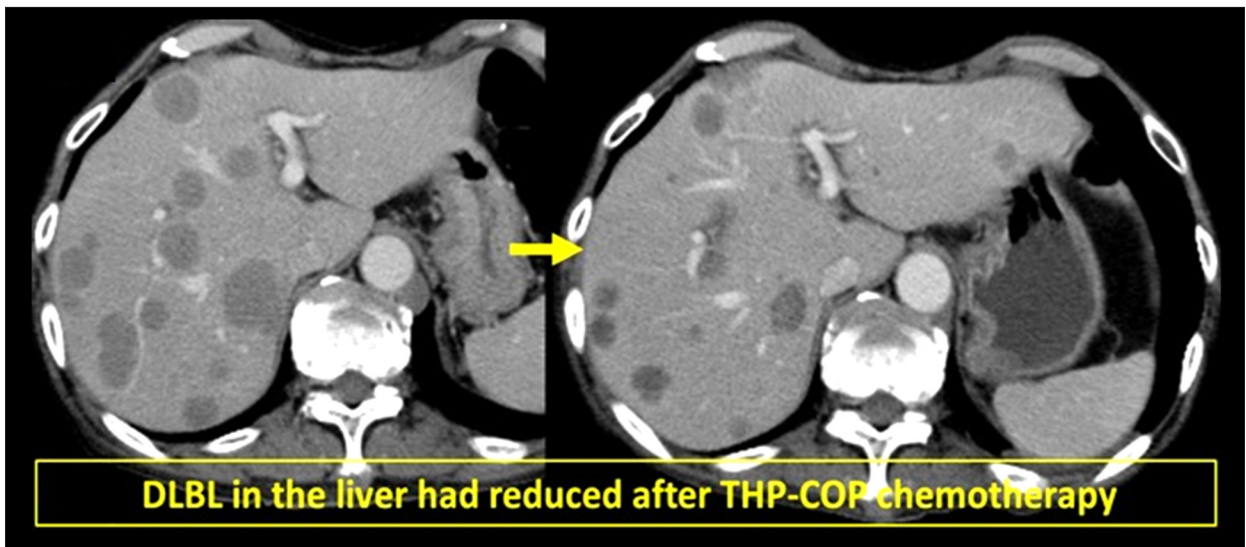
The mass in the liver was reduced in size after THP-COP chemotherapy in the abdominal CT.
